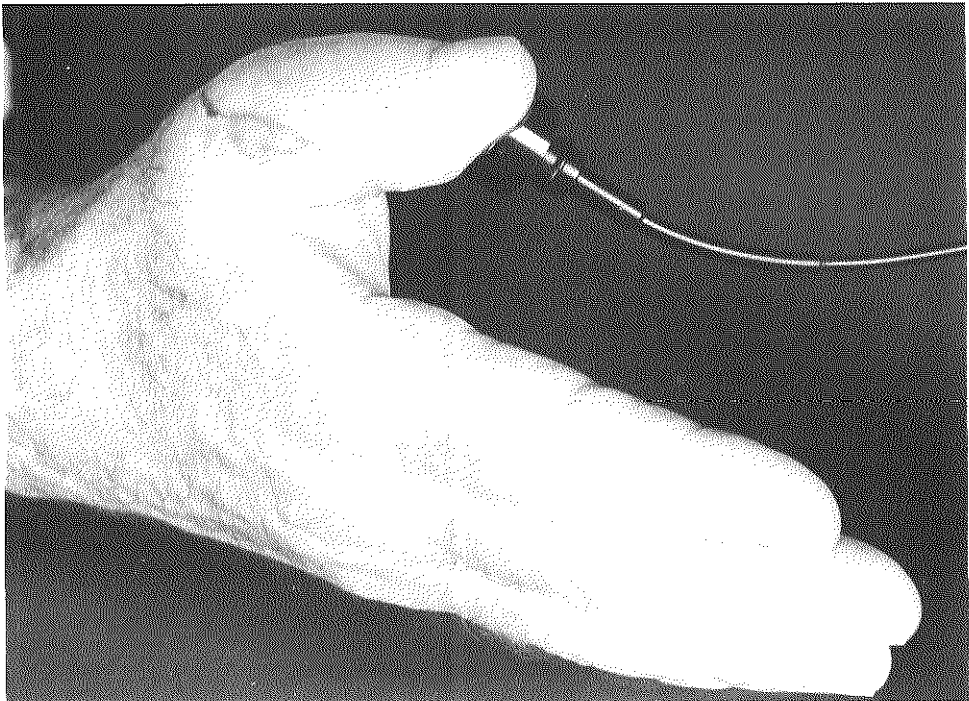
The laser Doppler probe placed on a replanted digit by means of a homemade laser Doppler probe holder with double-adhesive tape.
